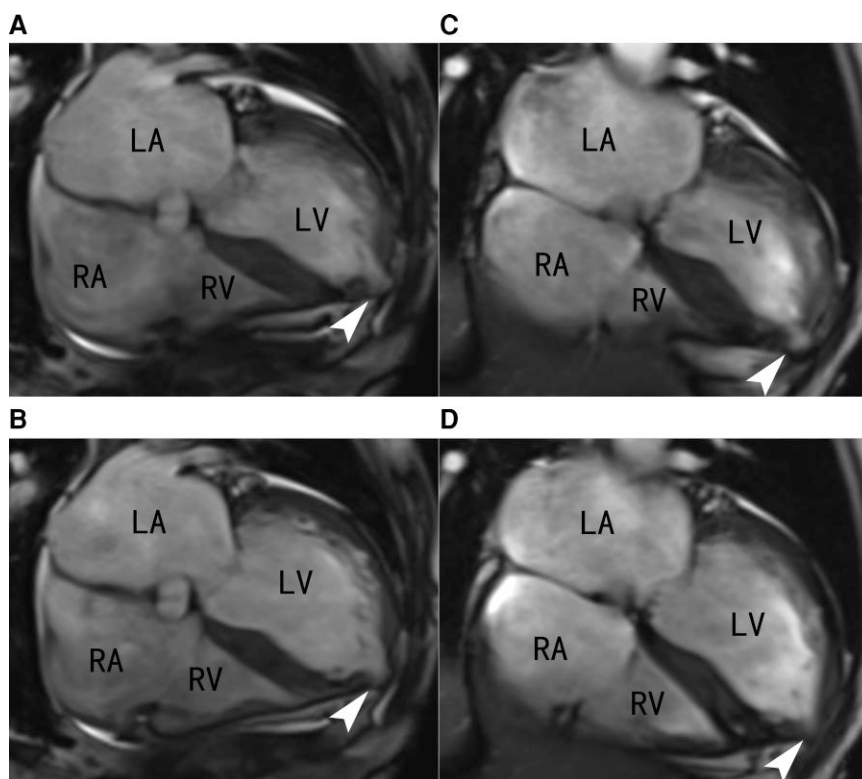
(A) Pre-procedural cardiac magnetic resonance imaging showing the left ventricular diverticulum (arrow) at the end of the systolic phase. (B) Pre-procedural cardiac magnetic resonance imaging showing the left ventricular diverticulum (arrow) at the end of the diastolic phase. (C) Post-procedural cardiac magnetic resonance imaging showing the left ventricular diverticulum (arrow) at the end of the systolic phase. (D) Post-procedural cardiac magnetic resonance imaging showing the left ventricular diverticulum (arrow) at the end of the diastolic phase.
